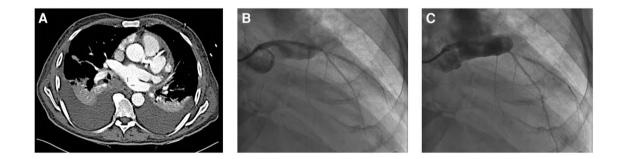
(A) In July 2021, computed tomography showed a progression of the aneurysm, measured $40 \times 33 \times 24$ mm. (B and C) Invasive coronary angiography shows the progression of the aneurysm preinterventionally.
